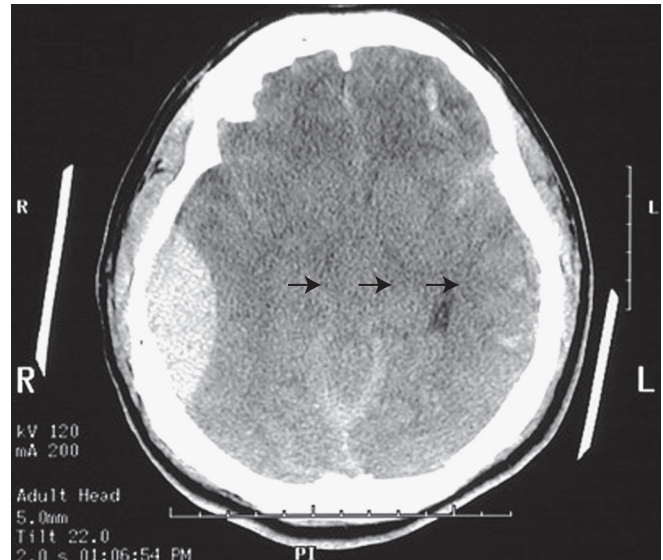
Epidural Hematoma, CT Image. Note the large right epidural hematoma with a lens-shaped outline as the smooth dura becomes indented against the underlying cortex on the right lateral aspect of the cerebrum. The epidural hematoma is confined within an area bounded by cranial sutures where the dura is firmly adherent to the skull. Note the mass effect with effacement of the lateral ventricles and the shift of midline to the left (arrows). In this case the individual fell from a height and struck the right side of his head, severing the middle meningeal artery. This epidural hematoma collected within hours. CT, Computed tomography. (From Klatt EC: *Robbins and Cotran atlas of pathology*, Philadelphia, 2006, Saunders.)
